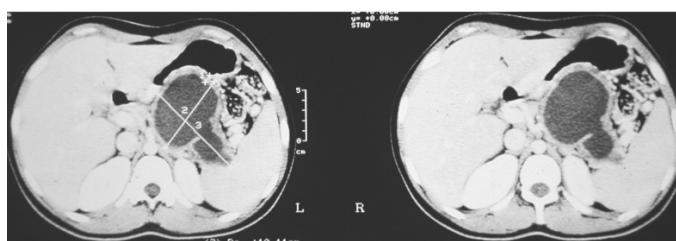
Abdomen CT of cyst in the Body and Tail region of the pancreas.
